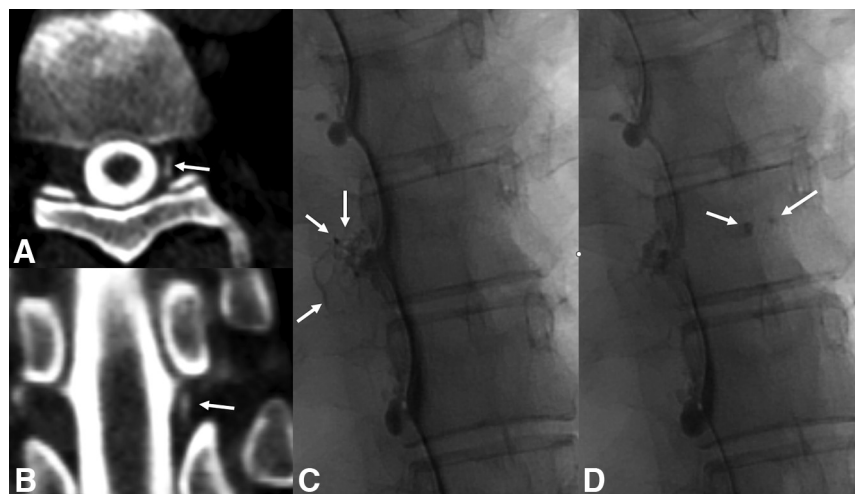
CVFs seen on conventional CT myelography and dynamic fluoroscopic myelography. Axial (A) and coronal (B) images from a conventional supine CT myelogram demonstrate subtle opacification of the internal epidural venous plexus (A and B, arrow), compatible with a CVF, which was subsequently confirmed on decubitus digital subtraction myelography (not shown). In a different patient, 2 AP images spaced 20 seconds apart from a left lateral decubitus dynamic myelogram (C and D) demonstrate a left T8 CVF involving several paraspinal veins (C, arrows), as well as the basivertebral venous plexus (D, arrows). The temporal resolution conferred by dynamic myelography is helpful to characterize the full extent of venous drainage.
